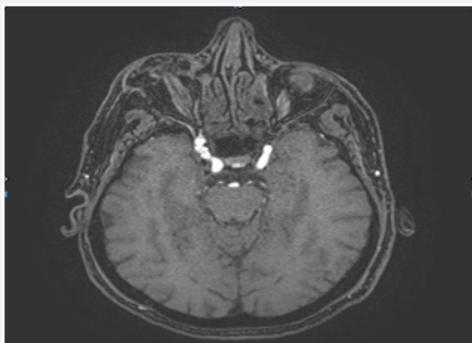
MRI: asymmetry between cavernous.
